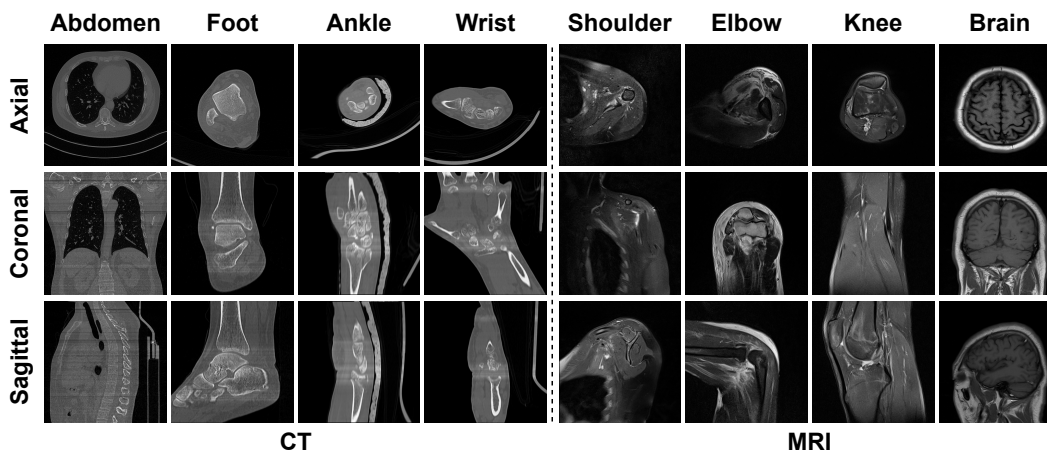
Examples of MORE dataset, containing CT and MRI scans from 4 different organs.
